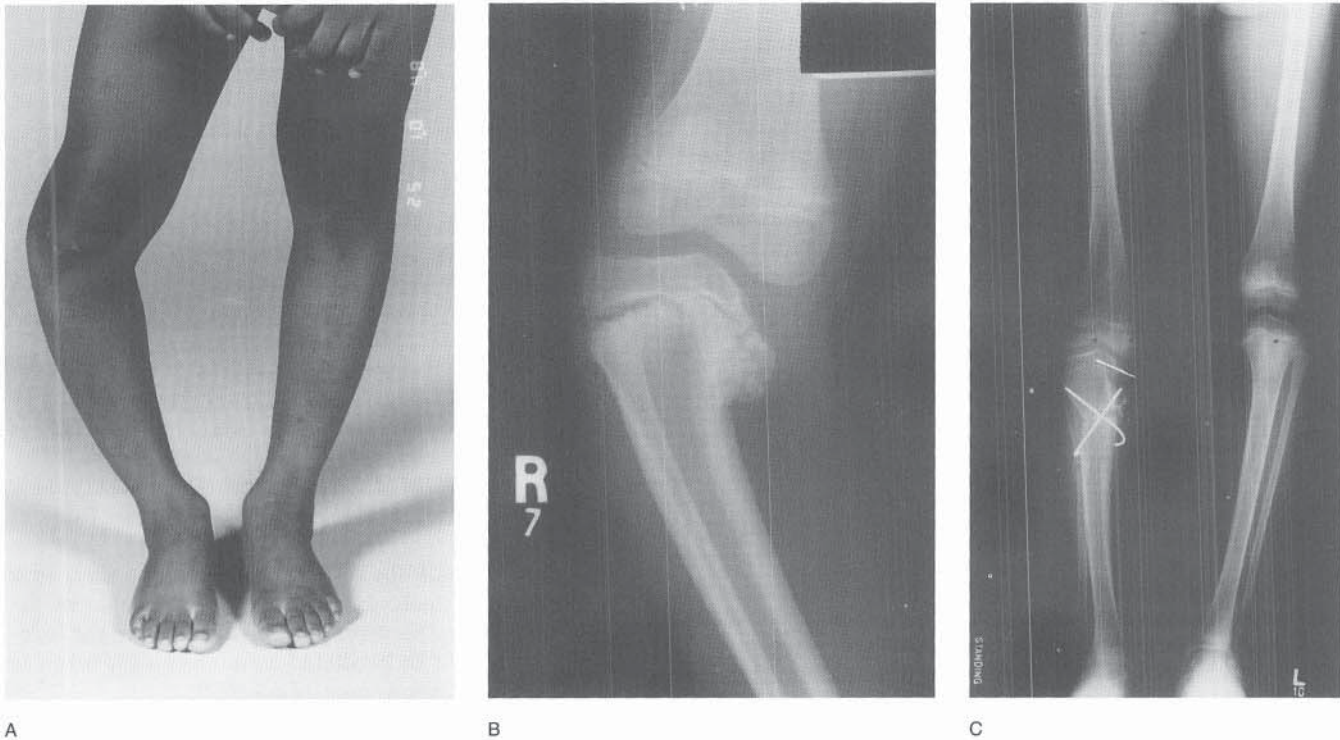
A and B, Clinical and radiographic appearance in a 6-year-old girl with a neglected deformity (stage IV–V). Simple osteotomy in such a case is associated with a 100 percent incidence of recurrence. C, Radiographic appearance following physal resection with a cranioplast interposition graft to prevent rebridging. Pins in the epiphysis anchor the interposed material. A corrective osteotomy to neutral mechanical axis was also performed. D, Radiographic appearance 6 years later. The deformity has remained corrected, with growth evident medially. The tibia on the right is 2 cm shorter than on the left. The patient is skeletally mature. E, Clinical appearance at age 13. The patient is asymptomatic.
